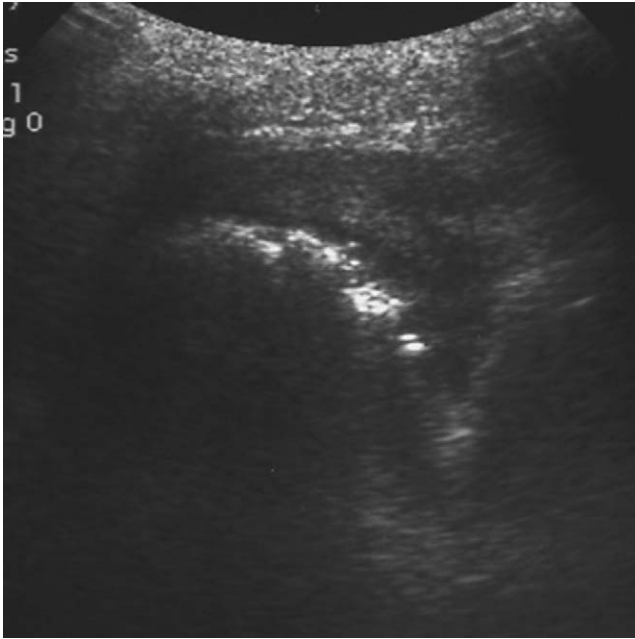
Chest ultrasound image reveals a pleural hyperechoic mass with intense sharply defined posterior acoustic shadowing.
